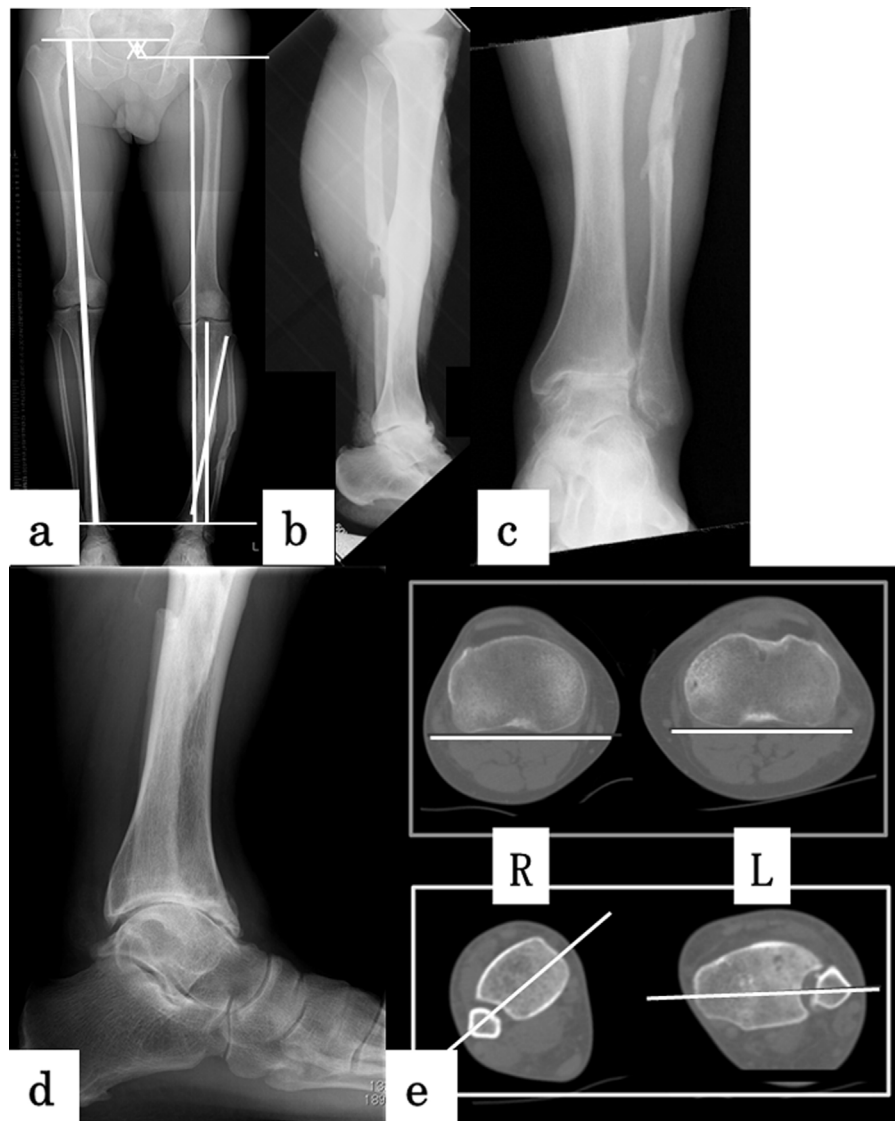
Imaging studies. (a) The mechanical axis passed through 5% of the knee joint from the medial edge. (b) X-ray imaging showed a varus deformity of 9° and a posterior apex angular deformity of 4° at the tibial shaft. (c and d) The patient's ankle joint exhibited widespread narrowing and Takura/Tanaka stage IV osteoarthritis. (e) CT revealed an internal rotation deformity of 37° .
